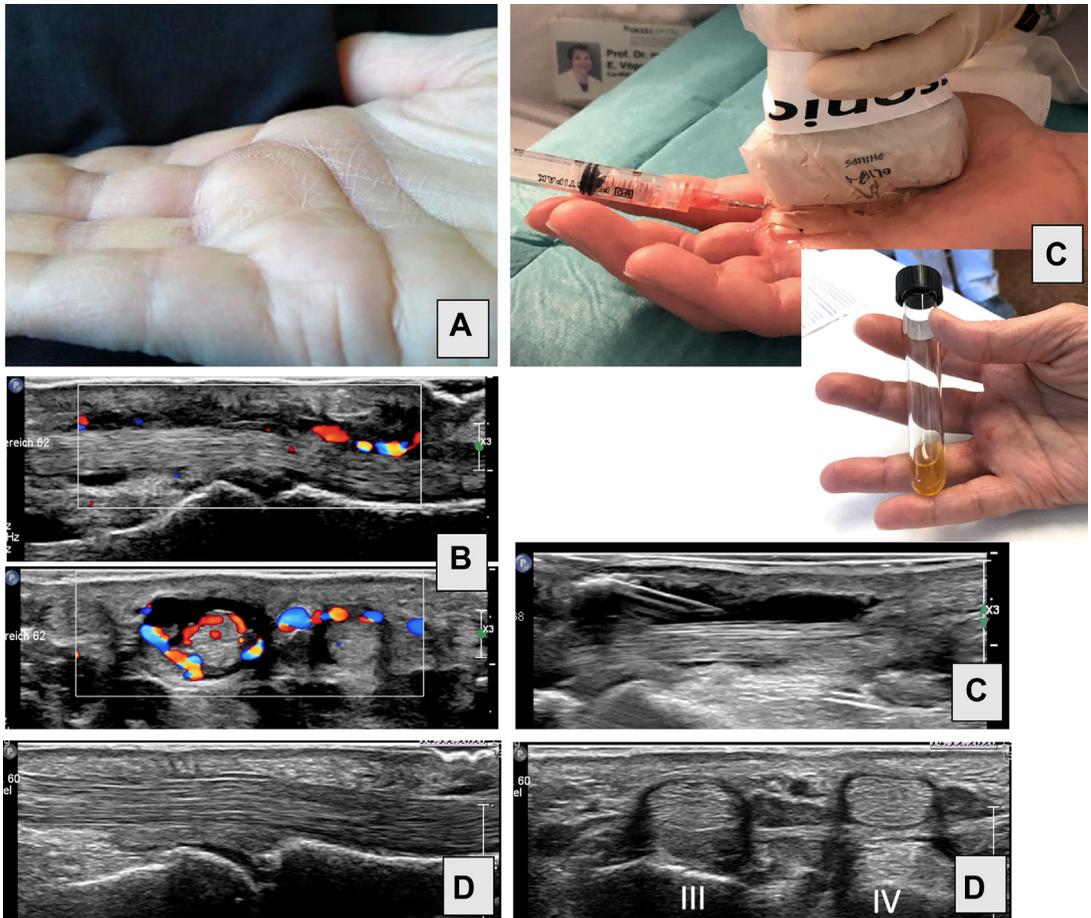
(A) Swelling and synovitis third finger and at A1 pulley, 5 weeks after A1 pulley release. (B) Hypervascularity and an echogenic fluid around flexor tendons of third finger, longitudinal and axial plane. (C) Sterile puncture of synovial fluid sonographically controlled, bacterial infection excluded. (D) Five months later normal appearance of A1 pulley and tendons longitudinal and axial.
